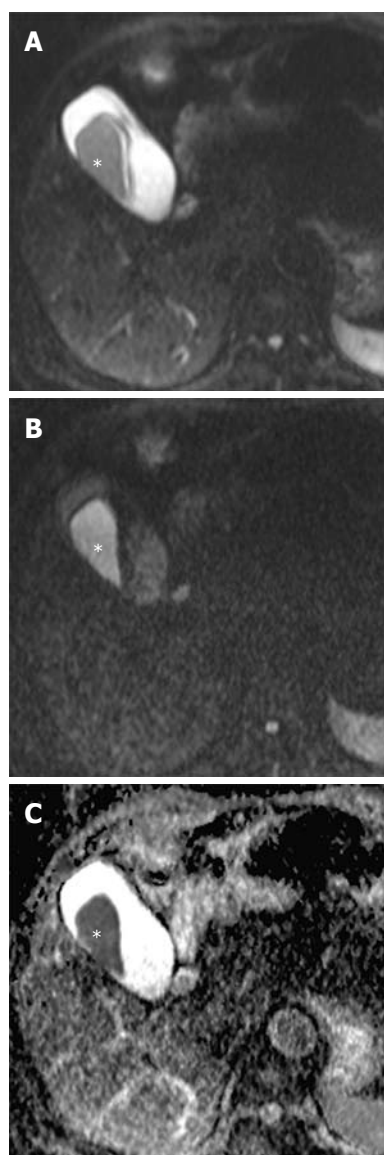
Hemobilia secondary to percutaneous liver biopsy in a 55-year-old man. A: DWI at $b = 50 \text{ s/mm}^2$ shows a hypointense hematoma in the gallbladder (asterisk); B: On DWI at $b = 800 \text{ s/mm}^2$, signal intensity of the hematoma changes to high signal (asterisk). C: On the ADC map, the hematoma in the gallbladder appears as low signal intensity (asterisk), which is associated with intact RBC membranes (i.e., hyperacute, acute, and early subacute hematomas). DWI: Diffusion-weighted magnetic resonance imaging; ADC: Apparent diffusion coefficient; RBC: Red blood cell.
